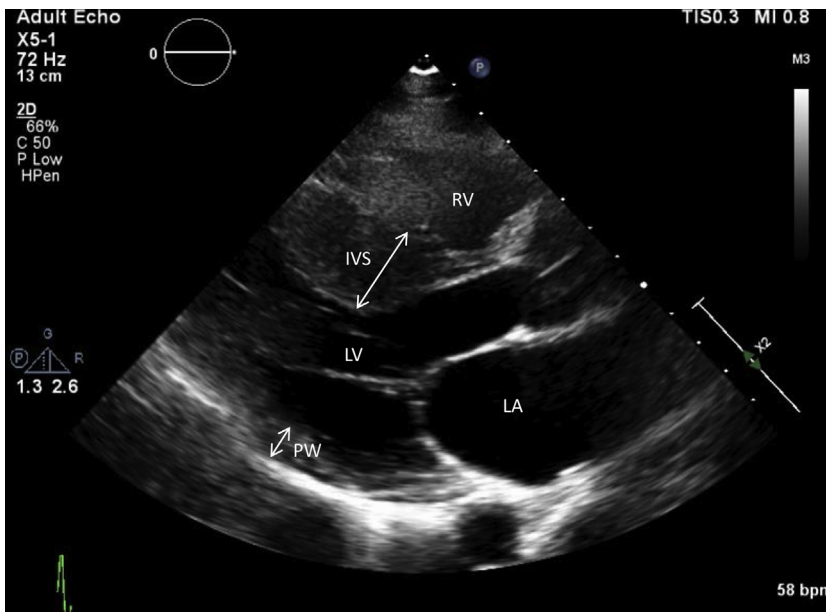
Hypertrophic cardiomyopathy. Echocardiographic image of hypertrophic cardiomyopathy showing asymmetric hypertrophy of the interventricular septum (IVS) relative to the posterior wall (PW) (double-headed arrows). LA, left atrium; RV, right ventricle.
